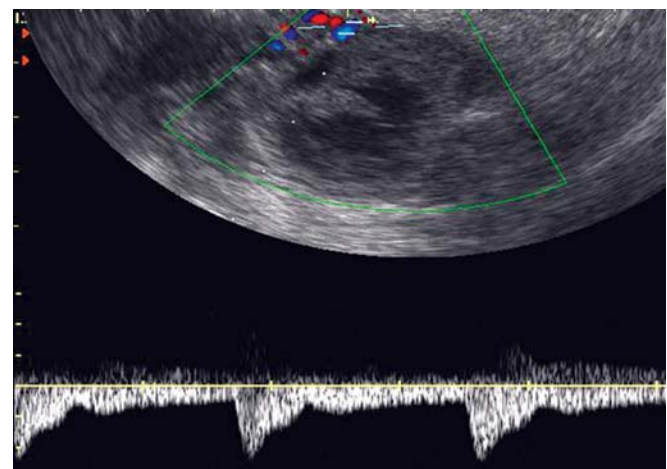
Spectral Doppler is often misleading in characterizing adnexal lesions. This is so because vessels in the periphery of the lesion are usually host vessels and may not show low impedance characteristics. Intratumoral vessels are low impedance circuits because tumor neoangiogenesis usually gives rise to vessels that lack muscle in their walls
